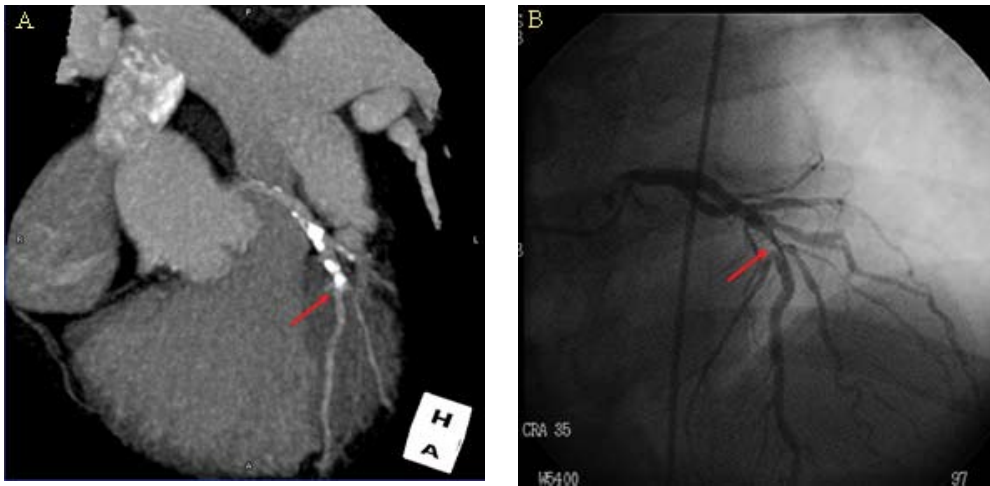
Panel A is a maximum intensity projection (MIP) Image from a CT angiography performed using a 16 detector CT scanner on a patient with atypical chest pain symptoms. This patient also had a conventional x-ray angiography performed shortly following the CT study. Calcified lesions are noted in the proximal left anterior descending artery (LAD) with a red arrow pointing to a high-grade lesion as shown on the still frame from the x-ray angiogram (Panel B) of the same patient.
